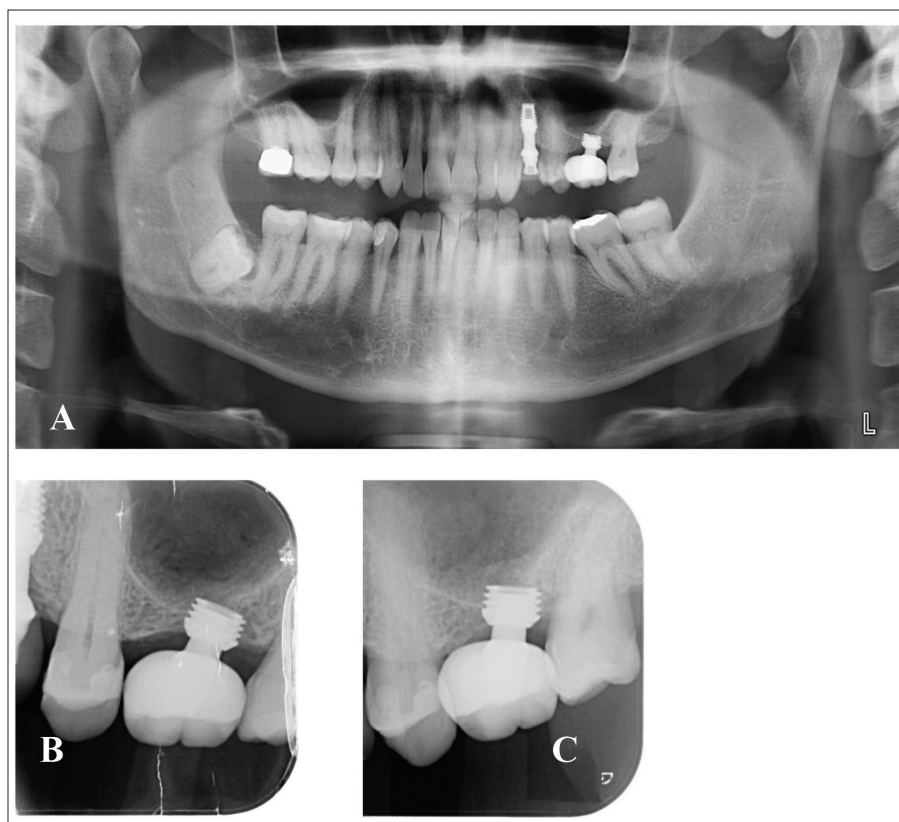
A. Orthopantomogram showing the definitive crown visible in the second quadrant B. periapical x-ray one year after implant loading. C. periapical x-ray examination three years after implant loading.
